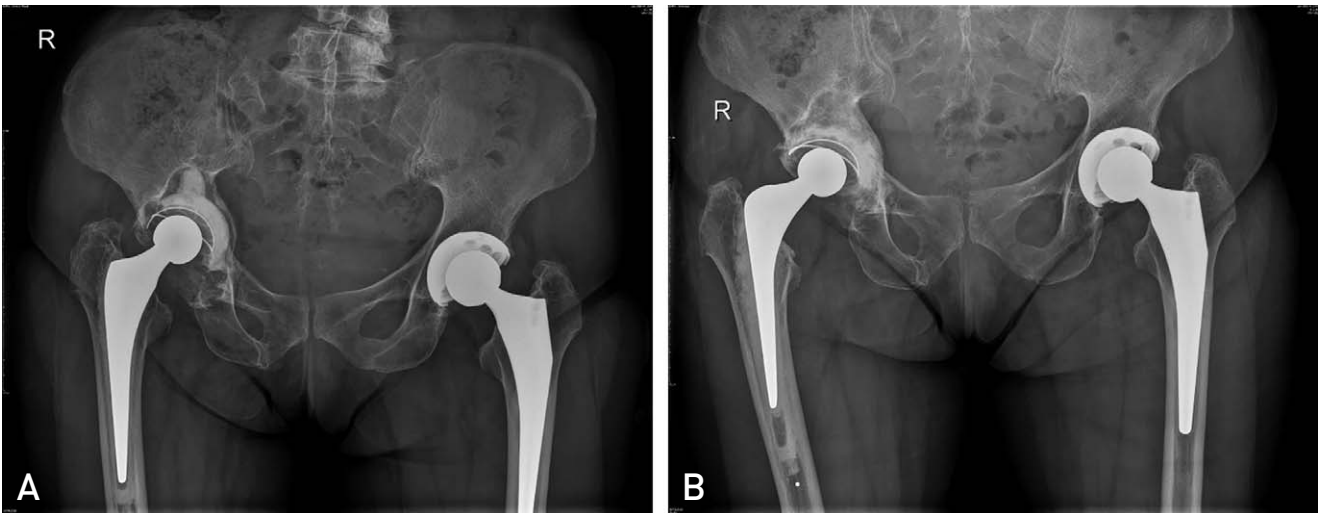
Radiographs of a 77-year-old female undergoing revision of a loose cemented acetabular component. Preoperative radiograph (A) and 5-year follow-up radiograph (B) after impaction bone grafting and cemented cup on right. Restoration of bone stock, leg length, and femoral offset as well as incorporation of graft is shown.
